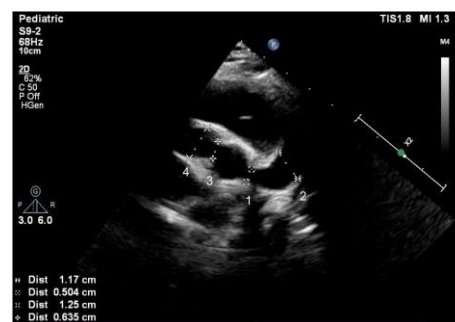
Echocardiography showing 1) Main left coronary artery, 2) Left anterior descending, 3) Right coronary artery, 4) Proximal Right coronary artery.
